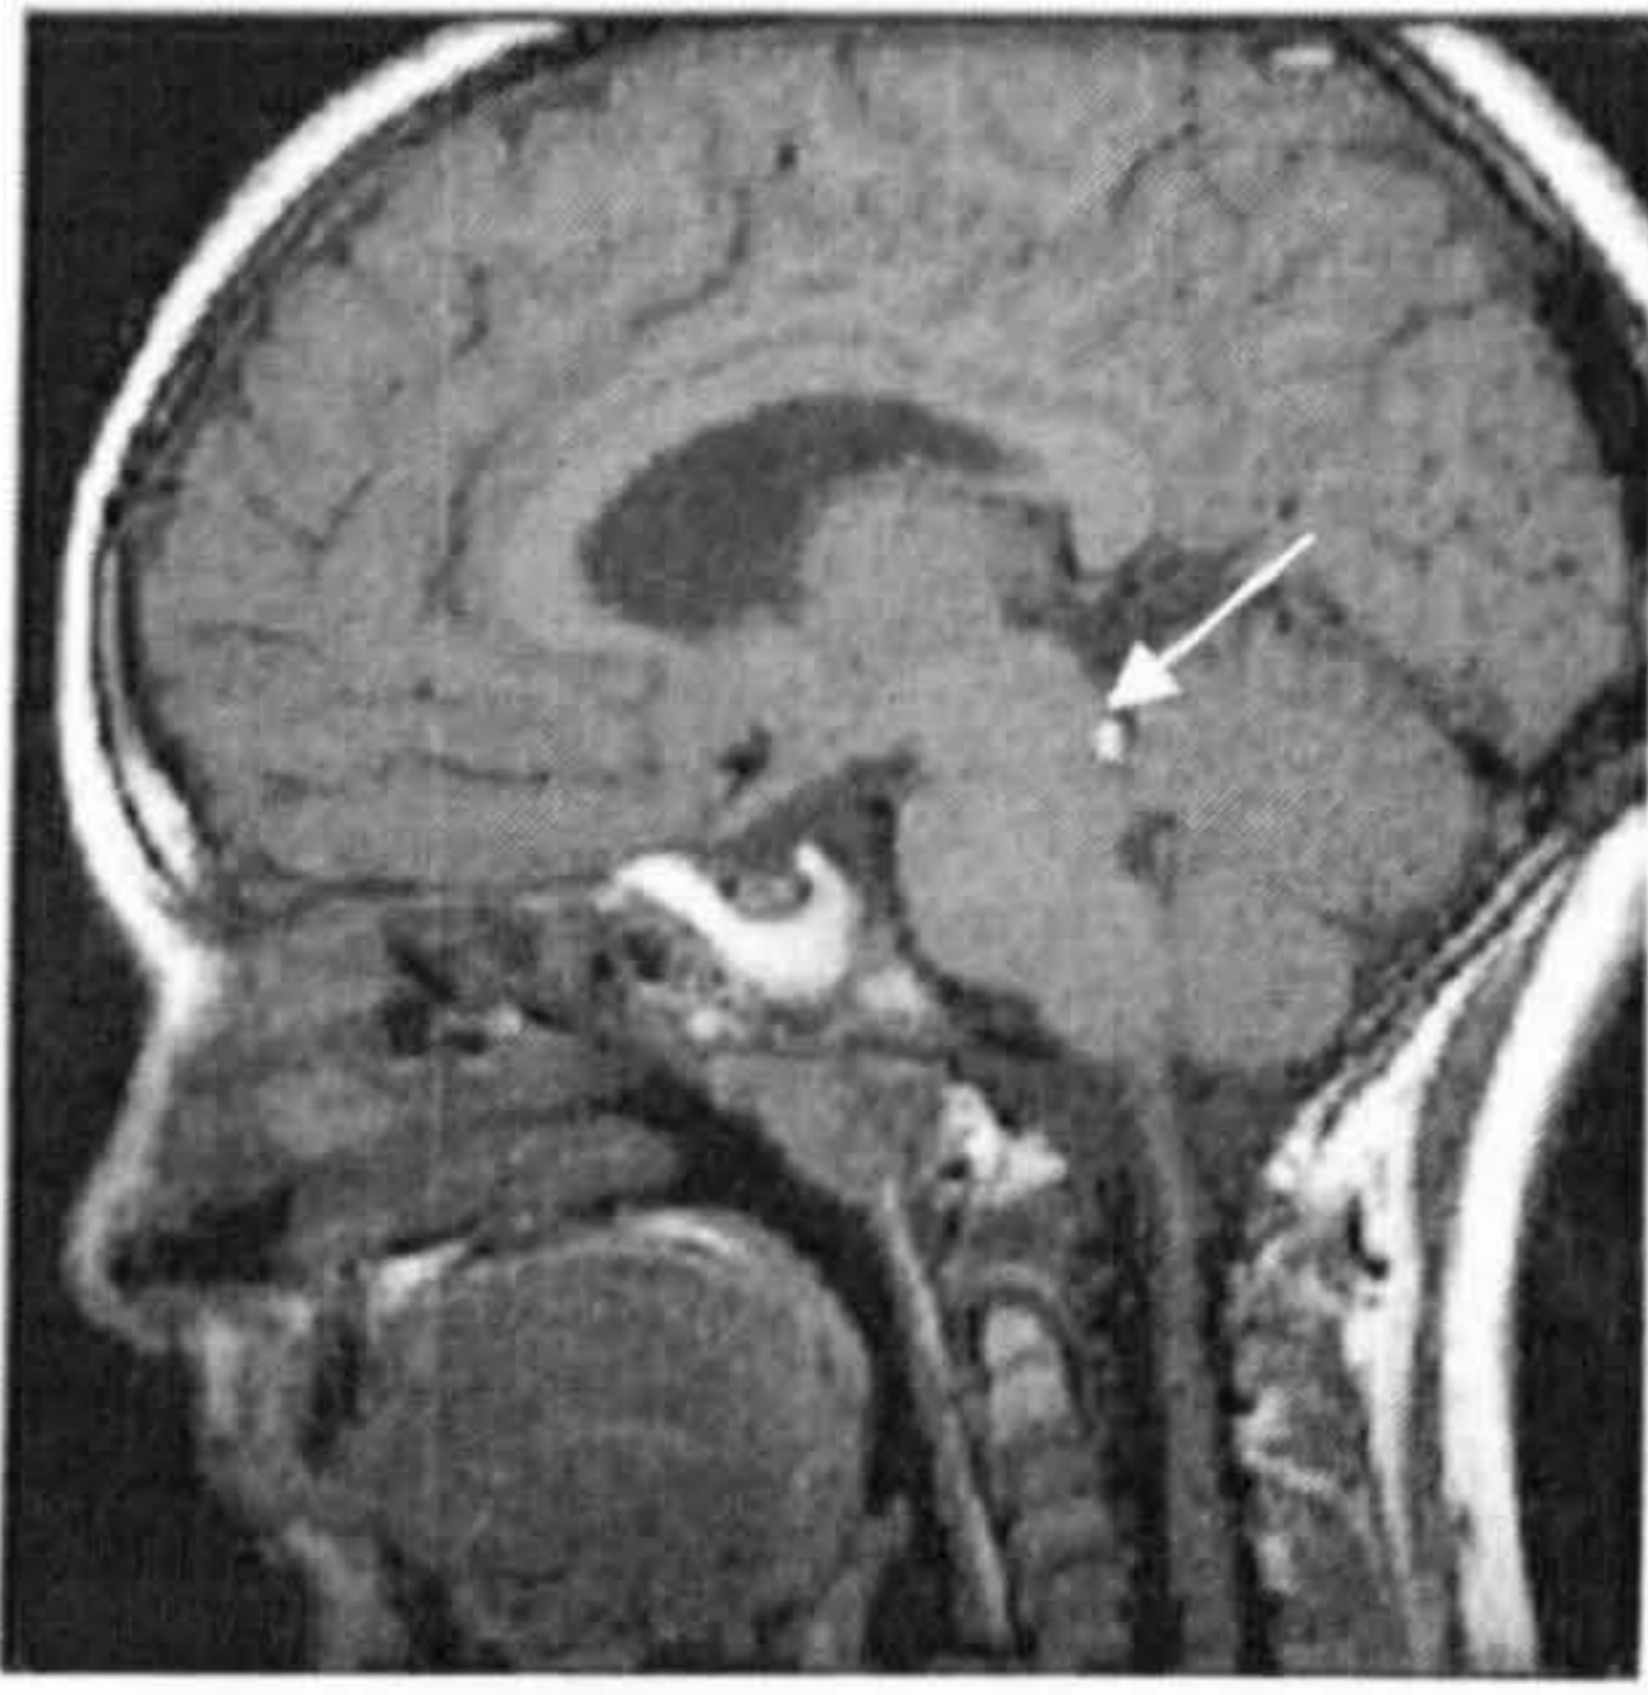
Chemical shift artifact [MRI-CHUQ 2003].
